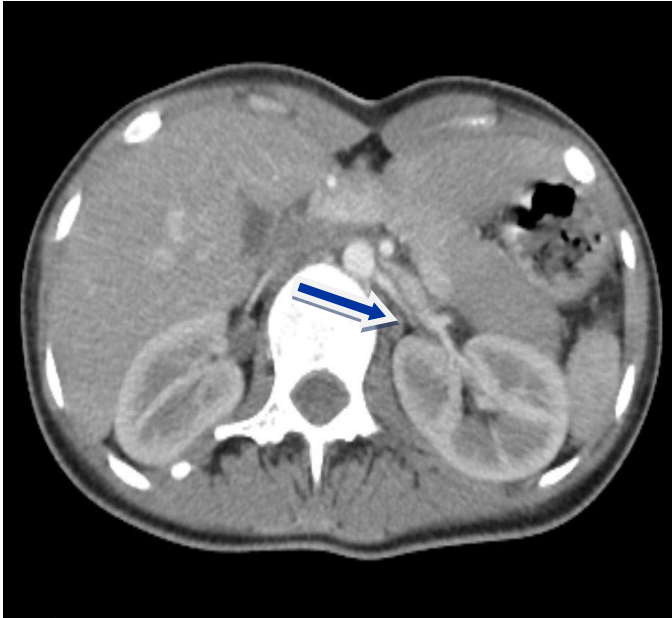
Abdominal CT scan after injection in axial section
